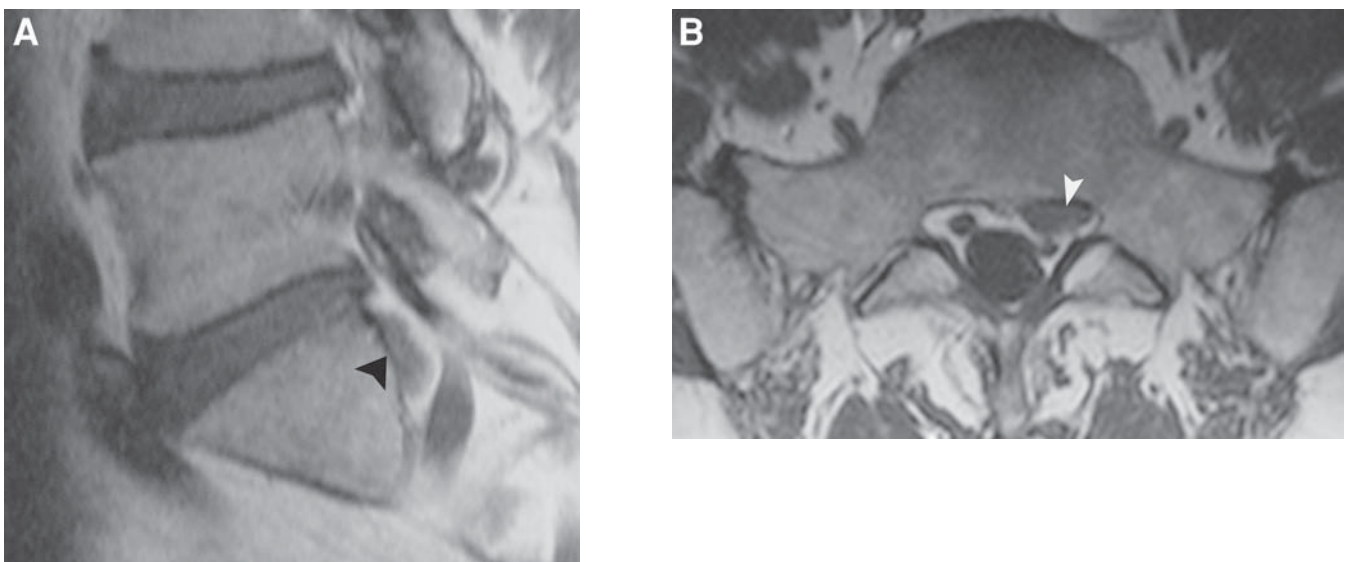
(A, B) Sagittal and axial MRI showing a free disc fragment compressing the exiting nerve root (*white arrowhead*) in a patient with severe radiculopathy.
